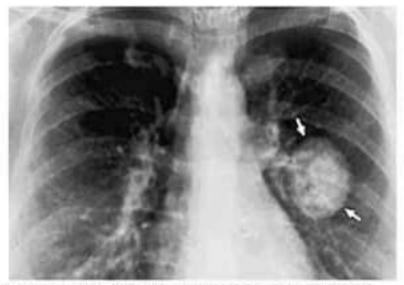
Chest X-ray lung mass showing pancoast tumor
